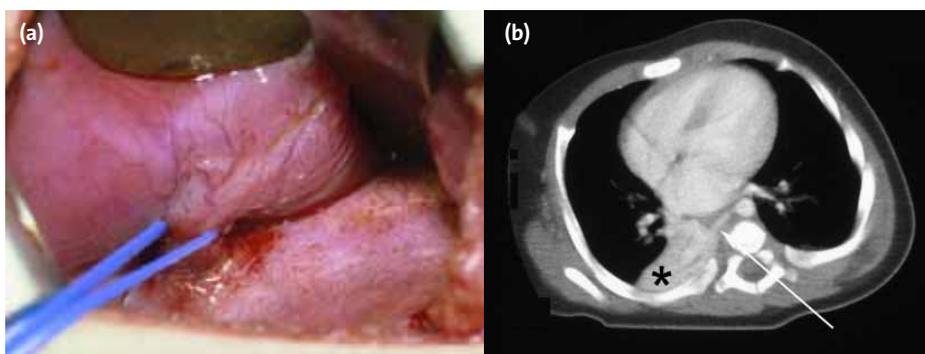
(a) Appearance of an extra-lobar sequestration at thoracotomy. The blue sling surrounds a large feeding vessel from the thoracic aorta. (b) Preoperative CT scan demonstrating the systemic arterial supply (arrow) to a sequestration (*).
